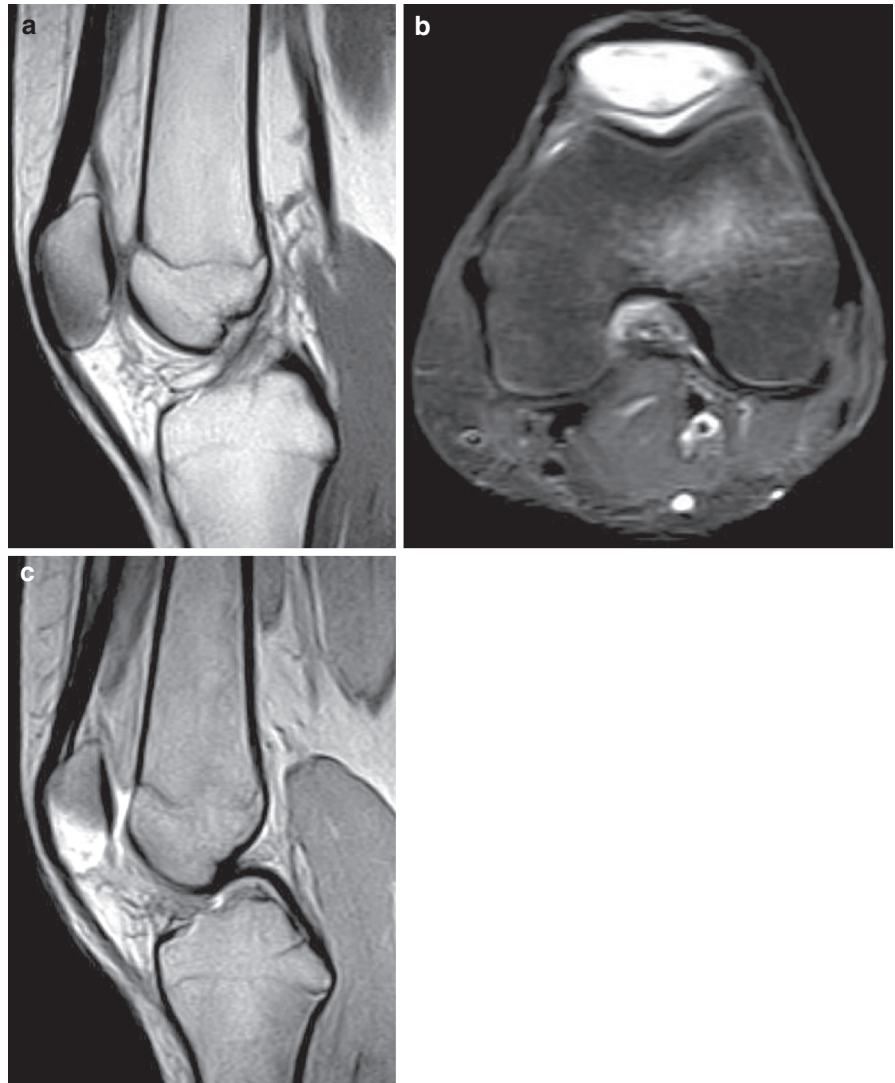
This patient had been suffering from anterior knee pain for several months caused by trauma due to a car accident. Conventional x-rays did not show any pathological finding. However, MRI did. (a) Sagittal SE T1W MR image. (b) Axial FSE PDW Fat Sat MR image. (c) Sagittal FSE T2W MR image
